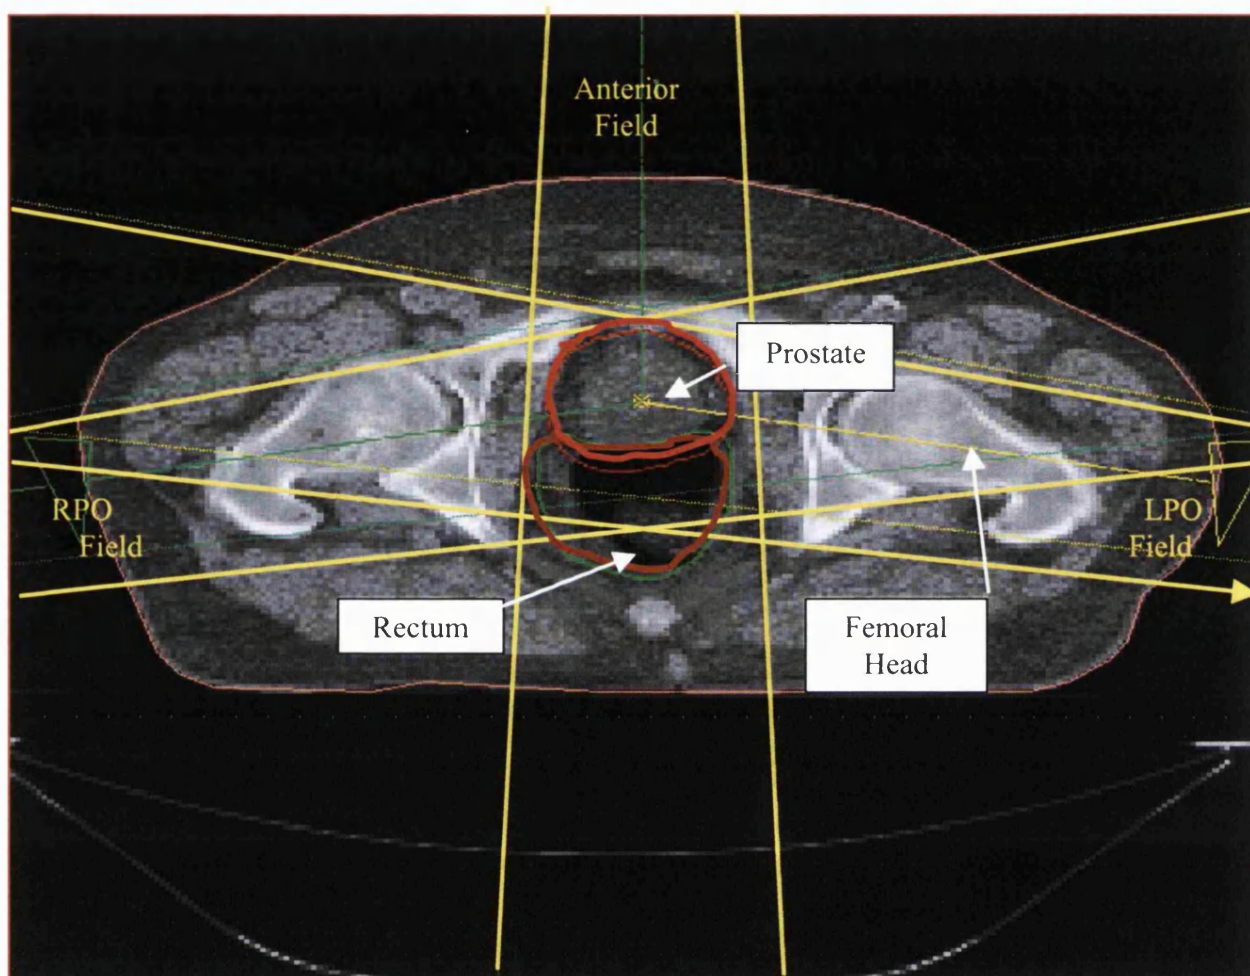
Central Planning CT Slice (Prostatic Carcinoma)
